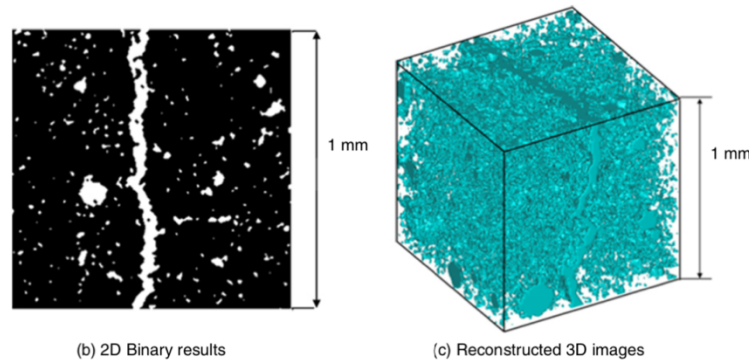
$\mu$ CT data processing for gas phase isolation. Reprinted with permission from [22].
